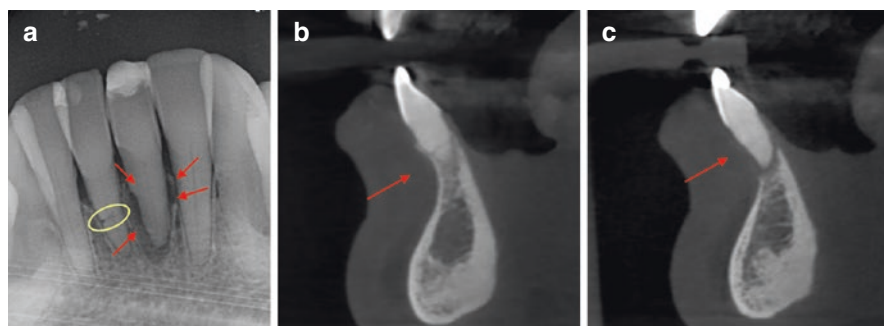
Horizontal root fractures after dental trauma on central mandibular incisors. The periapical radiograph was taken 1 month after the trauma. A horizontal root fracture is easily detectable on the right central incisor (yellow circle). However, on the left central incisor, the horizontal root fracture is not visible; note the bone lesion around the left central mandibular incisor (a). Horizontal fracture on the right central mandibular incisor on CBCT section (b). Horizontal fracture on the left central mandibular incisor on CBCT section (c)
